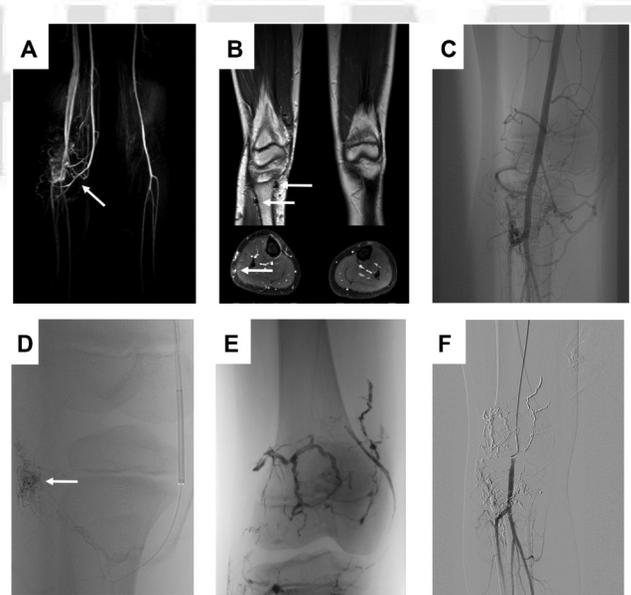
Fast-flow arteriovenous malformation in a 10-year-old girl. (A) Typical MRI presentation of a fast-flow AVM, located around the right knee with multiple feeding arteries arising from the superficial femoral artery, popliteal artery, and anterior tibial artery, with early venous filling of the femoral vein due to AV shunting. (B) Flow-voids representative for fast-flow lesion could be detected around the knee (arrows) and additionally within draining veins (lower panel in B) in the subcutaneous fat (arrow), as sign of arterialized venous flow patterns. (C) Transarterial angiogram shows multiple dysplastic arteries feeding a central nidus from multiple sites. (D) Positioning of the microcatheter within the AVM nidus for subsequent transarterial embolization. (E) Following extensive embolization the dark EVOH cast can be seen with dysplastic AVM vessels. (F) Post-embolization angiogram reveals subtotal occlusion of the AVM with patent lower limb arteries. Of note, subsequent embolization sessions were required in this case to achieve a complete devascularization of the AVM.
